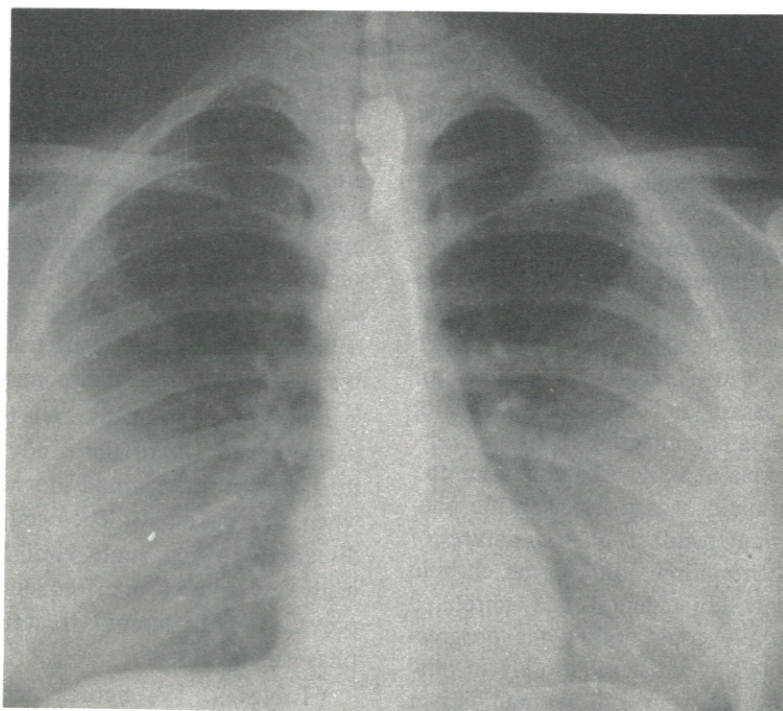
Thoracic roentgenogram shows displacement of barium filled esophagus by right aortic arch. Also note vascular groove produced by aberrant left subclavian artery.
